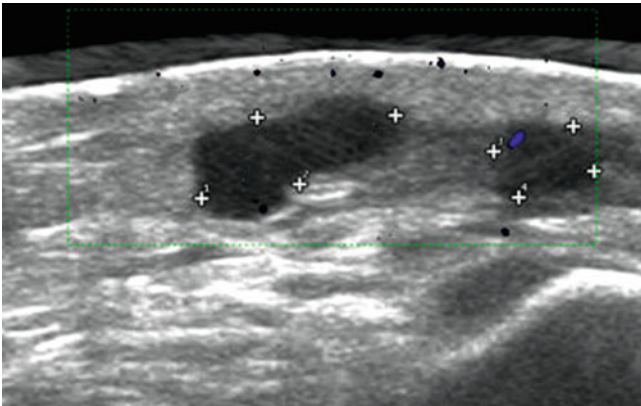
Echo-poor aspect of in-transit metastases. Directional power Doppler image. Slightest traces of vascularization give the right hint towards in-transit metastases, which have been proved by fine-needle aspiration cytology
